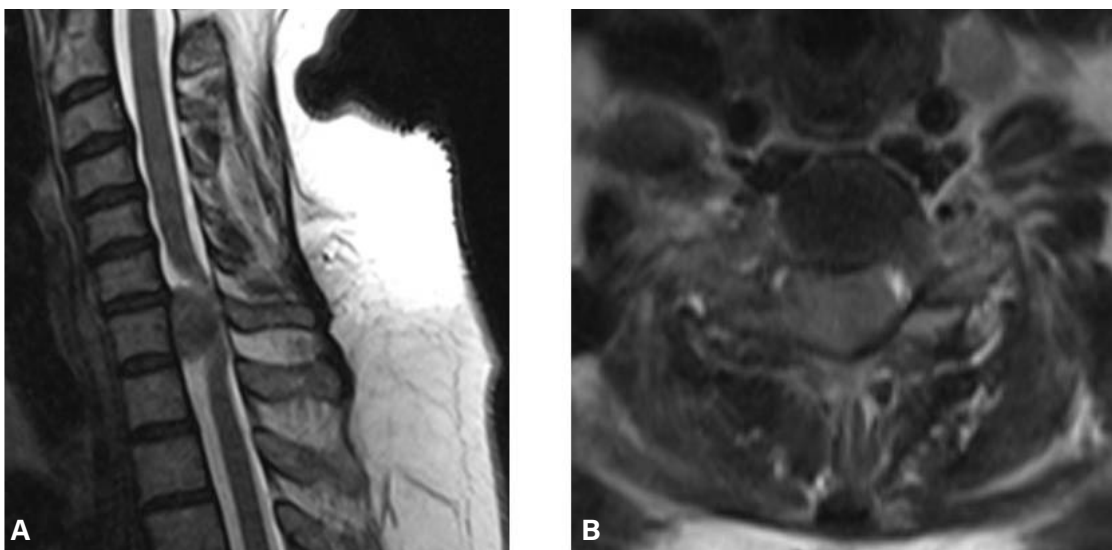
A) Preoperative cervical sagittal T2 MRI. B) Preoperative cervical axial T2 MRI.
